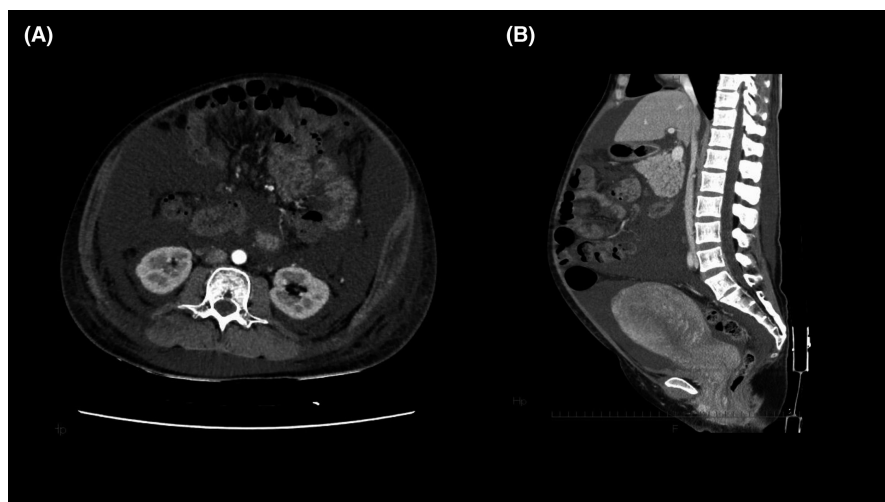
Computed tomography demonstrating the accumulation of massive ascites. (A) Transverse plane. (B) Sagittal plane
